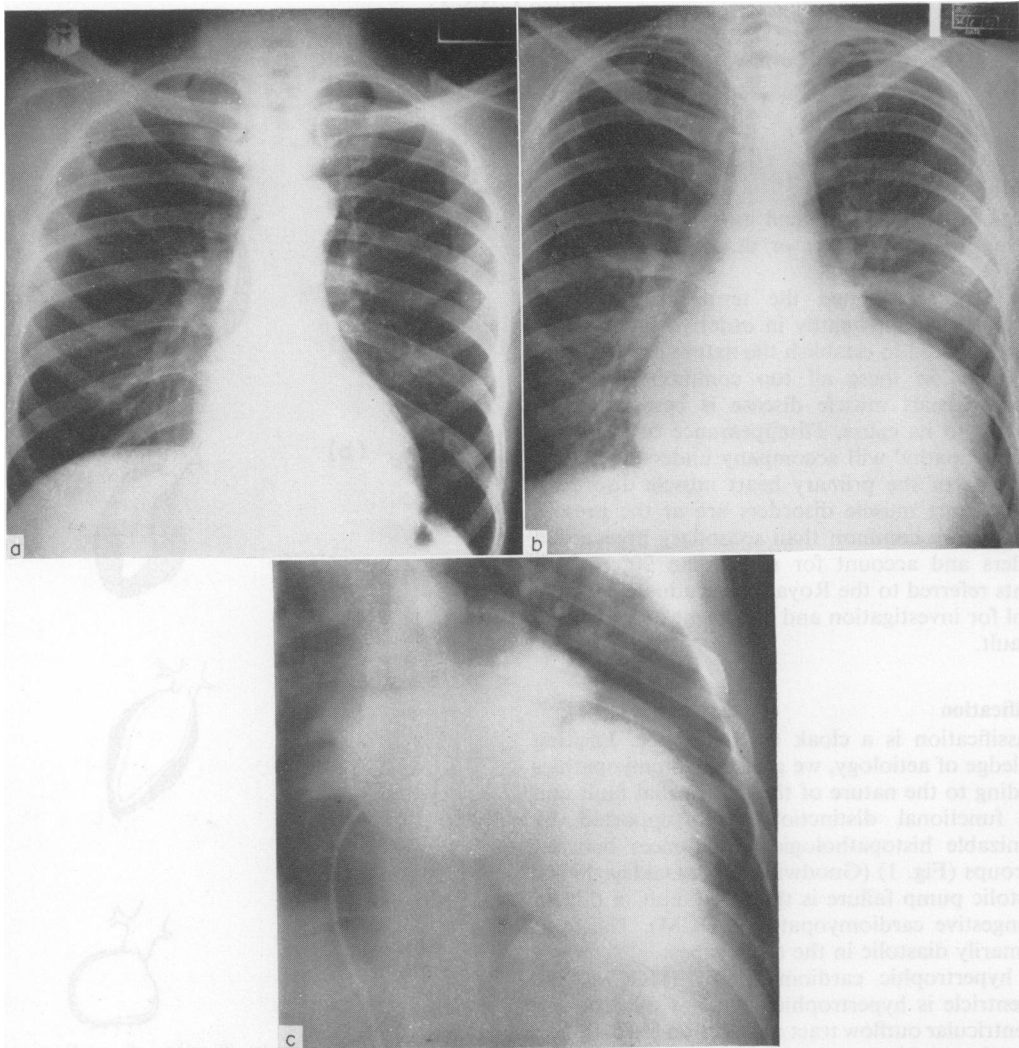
(a) Plain radiograph of the chest in COCM showing left ventricular enlargement; (b) plain radiograph of the chest in COCM showing greater left ventricular enlargement in a more advanced case; (c) angiogram of the left heart chambers showing gross dilatation of the left ventricle at an advanced stage of COCM.
